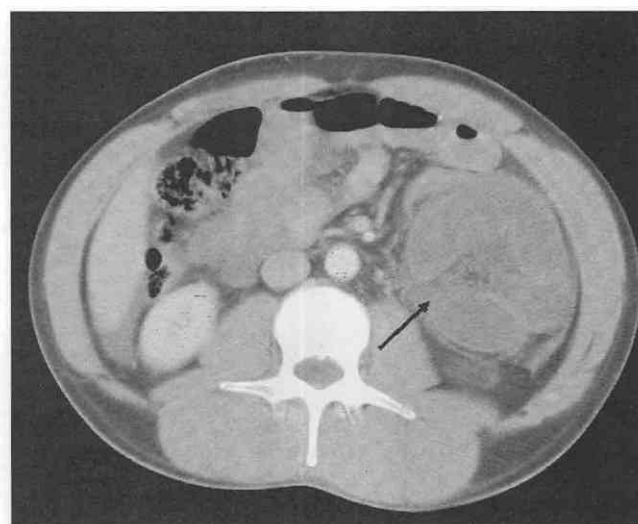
CT scan shows how beneficial IV contrast material is for a correct diagnosis. The fluid-density chump of bowel (*arrow*), representing an internal hernia, can be correctly identified because the contrast material enhances the bowel wall and valvulae. Without contrast material, it would exhibit a fluid density indistinguishable from that of an abscess.
